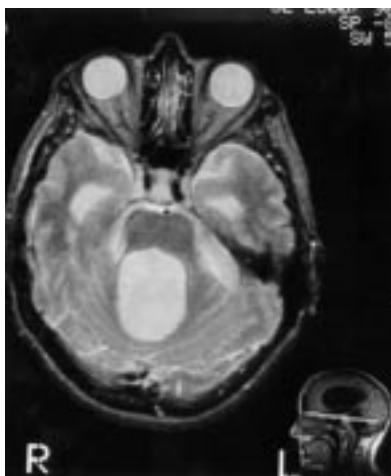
Brain MRI of patient III-2 showing communicating hydrocephalus.
